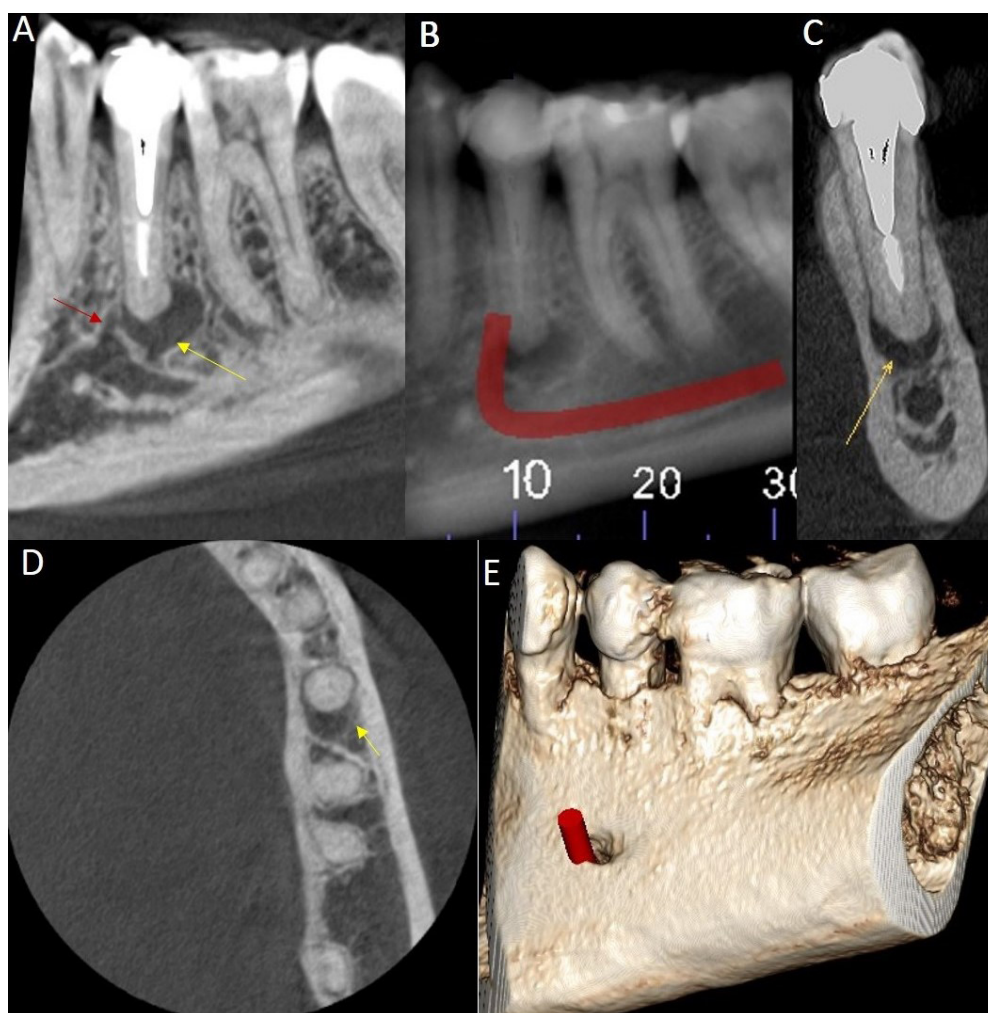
Cone beam computed tomography of tooth #35. (A, B) (sagittal plane), the *yellow arrow* shows the periapical lesion, and the *red arrow* shows the mental foramen. Also, the trajectory of the mental foramen is indicated by *red curve*. (C, D) (coronal and axial sections, respectively), the *yellow arrow* shows the periapical lesion between the buccal and lingual cortical bone. (E) volumetric reconstruction showing the mental foramen close to the apex of tooth #20.
